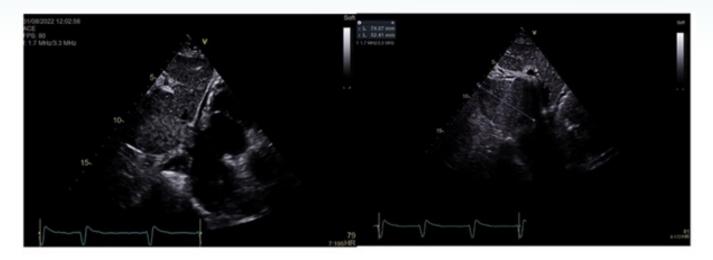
Transthoracic echocardiogram. Left – Subcostal long-axis view: inferior vena cava mass. Right - Inferior vena cava mass dimensions (74 x 52 mm)
